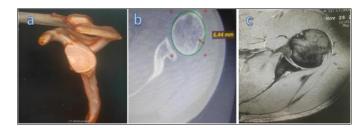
(a) 3-D CT glenoid en face view showing glenoid bone defect; (b) Axial CT, (c) Axial MRI showing humeral bone defects.
